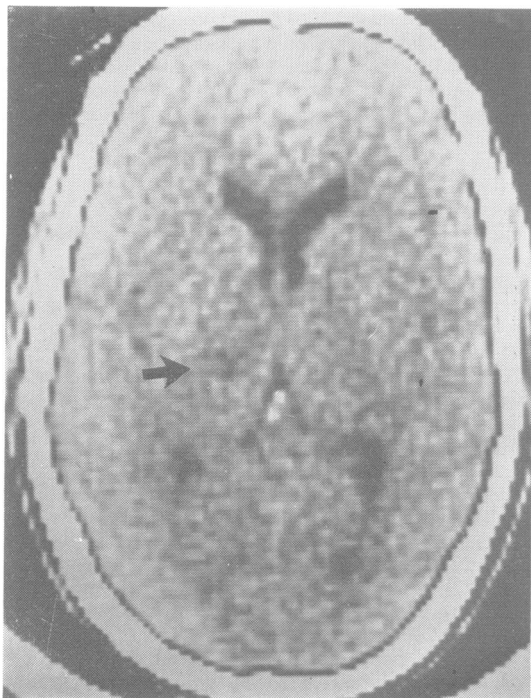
CT scan of patient 2 performed 2 weeks after onset of symptoms.
